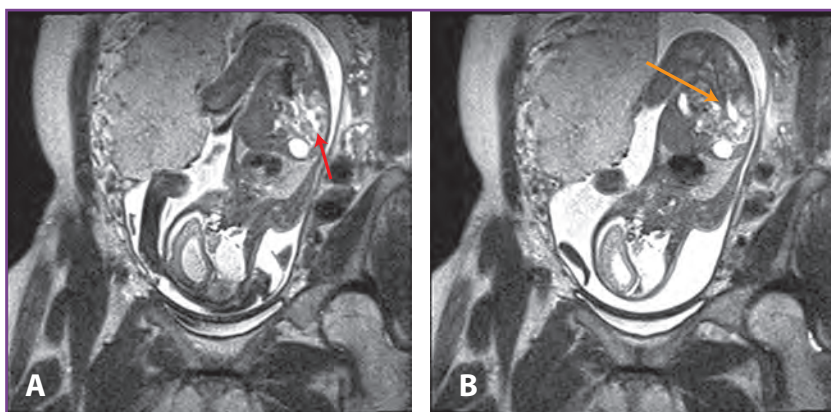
Fetal magnetic resonance images in a fetus of 25 weeks' gestational age show mild dilation of the renal pelvis of the left kidney. A, Arrow notes caliectasis of the left kidney. B, Arrow denotes fullness of the proximal left ureter.
